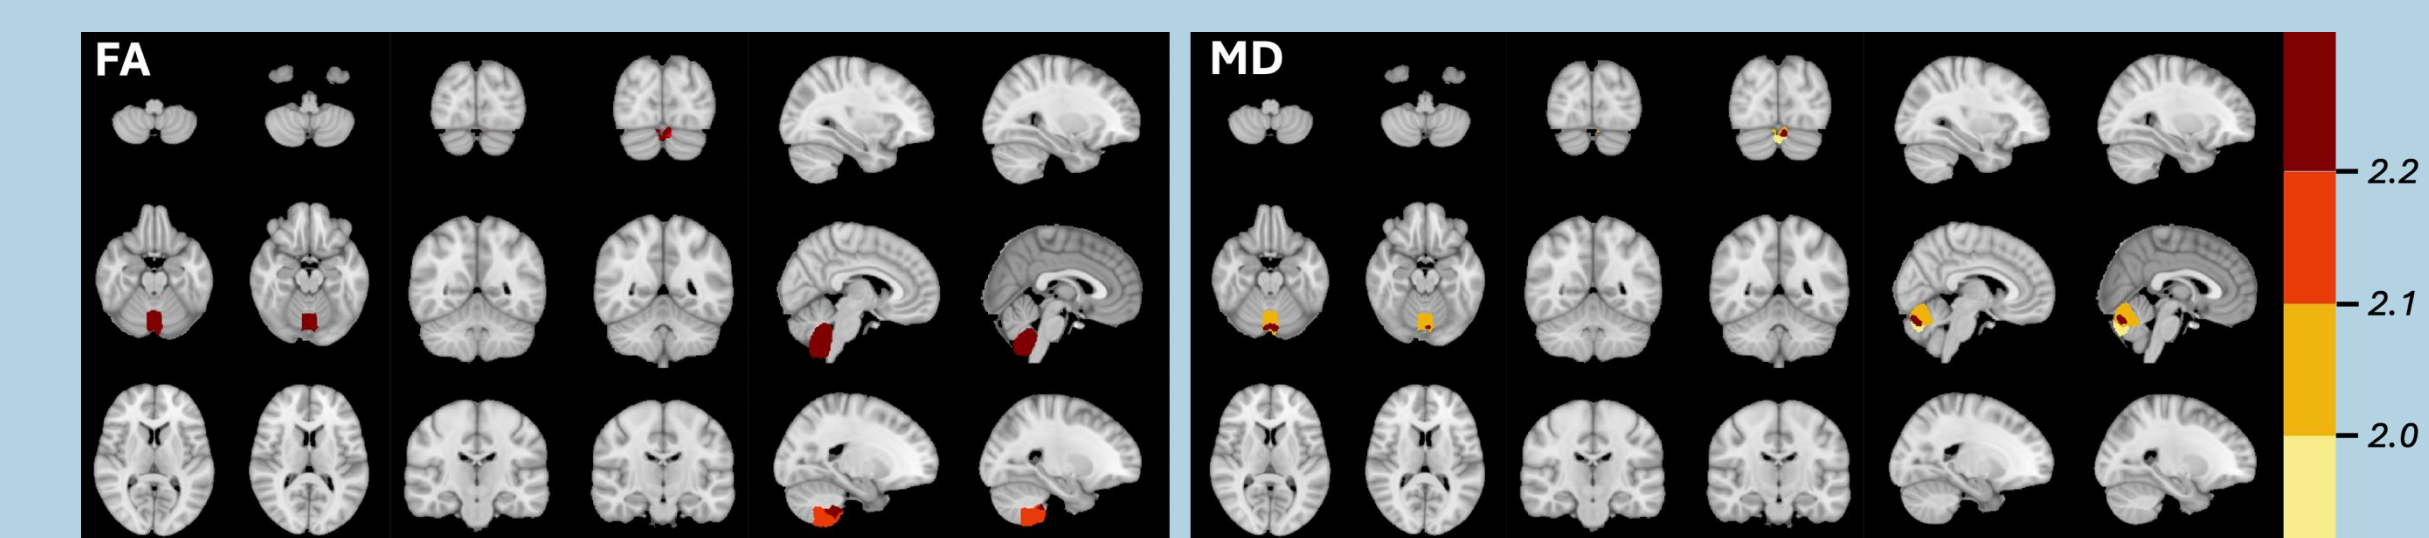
Severity maps of sagittal brain slices showing localized cerebellar damage clusters in a patient suffering from mTBI. Z-scores >2 standard deviations (significant injury) are colour coded orange to dark red to indicate increasing severity. Panels display standard MRI metrics of neuronal integrity labelled as FA (fractional anisotropy) and MD (mean diffusivity).
